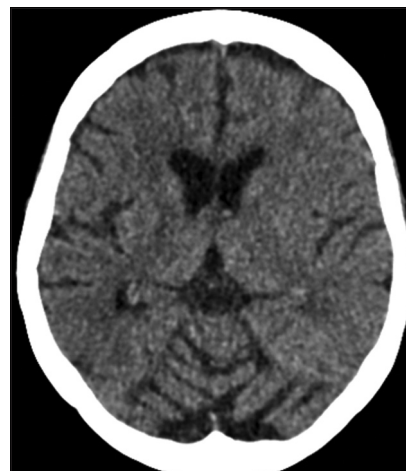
Conventional unenhanced CT performed 24 h post procedure showing resolution of hyperdensity.
